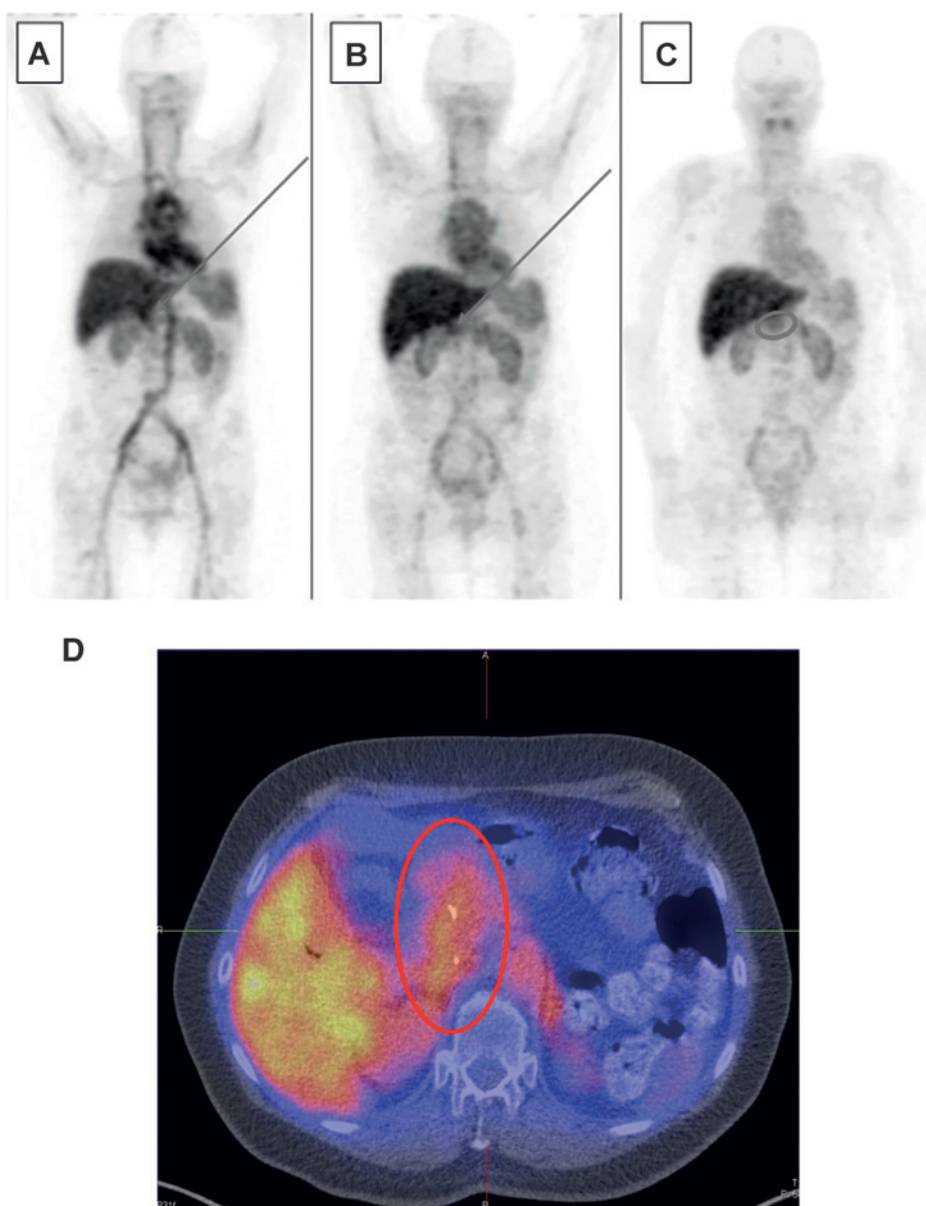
^{89}Zr -MMOT0530A PET in a pancreatic cancer patient day 2 (A), day 4 (B), and day 7 (C) after tracer injection, showing whole-body distribution with highest uptake in circulation (heart), liver, kidneys, and primary tumor (red circle). A fusion with diagnostic CT shows the primary pancreatic tumor (red circle) and the high liver uptake in healthy liver (D).
